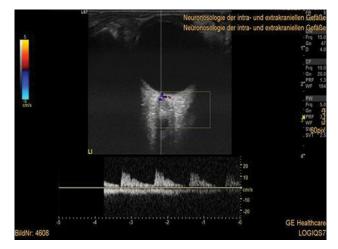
Transorbital approach for ultrasound investigation presents a preserved flow of the left central retinal artery.
